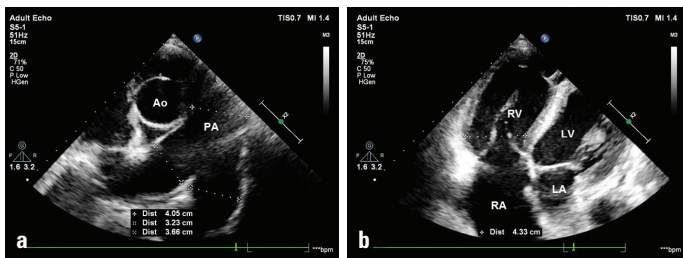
(a) Parasternal short axis view of dilated pulmonary arteries. (b) Apical four chamber view. Ao - aorta, LA - left atrium, LV - left ventricle, PA - pulmonary artery, RA - right atrium, RV - right ventricle
